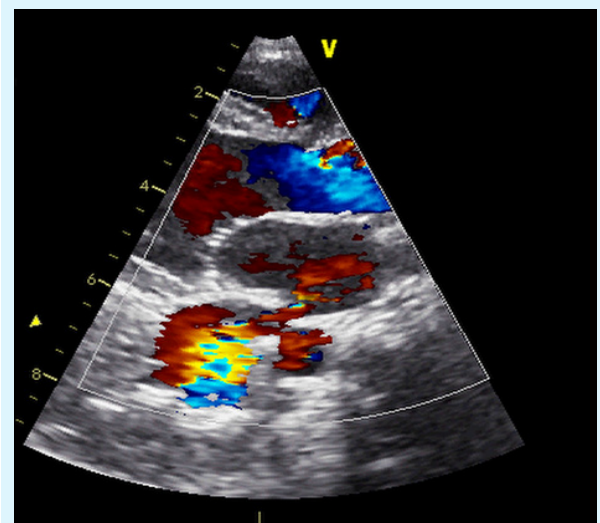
parasternal view: color turbulence at the left inferior pulmonary vein
